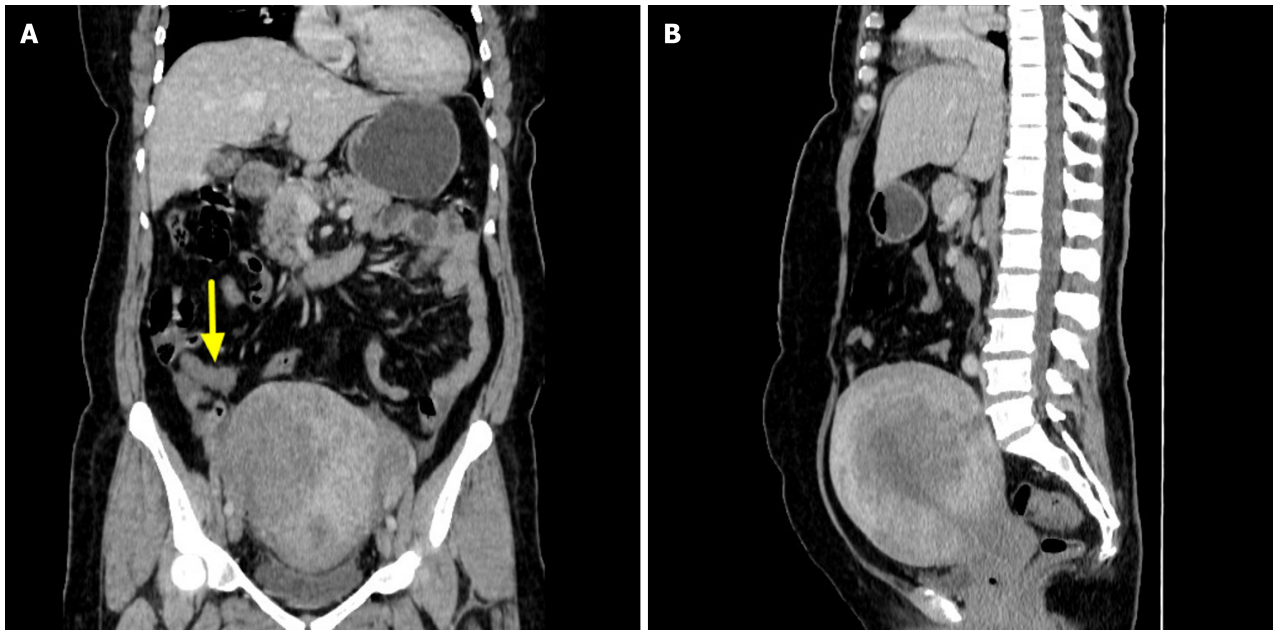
Computed tomography features of the appendix and uterus. A: Computed tomography (CT) enhanced coronal view: Coarsening appendix (arrowhead), strengthening after enhancement, clear boundary between focus and surrounding tissues; B: CT enhanced sagittal view: Obvious uterus enlargement, obvious muscular.
